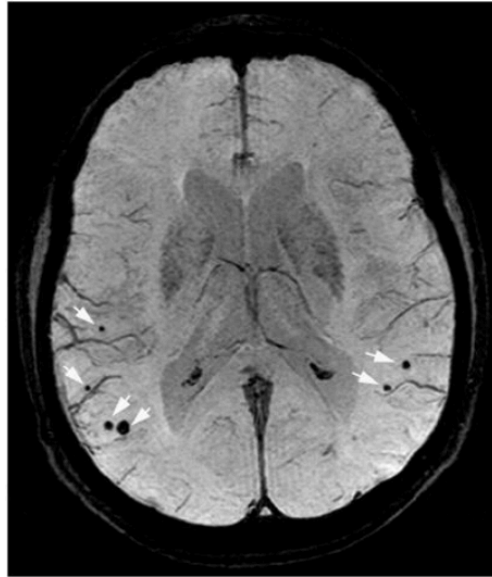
The image uses a minimum intensity projection of a T2*-weighted MRI (4 mm slab) to show CMBs (highlighted by the arrow) near vessel flow voids on the brain surface.
